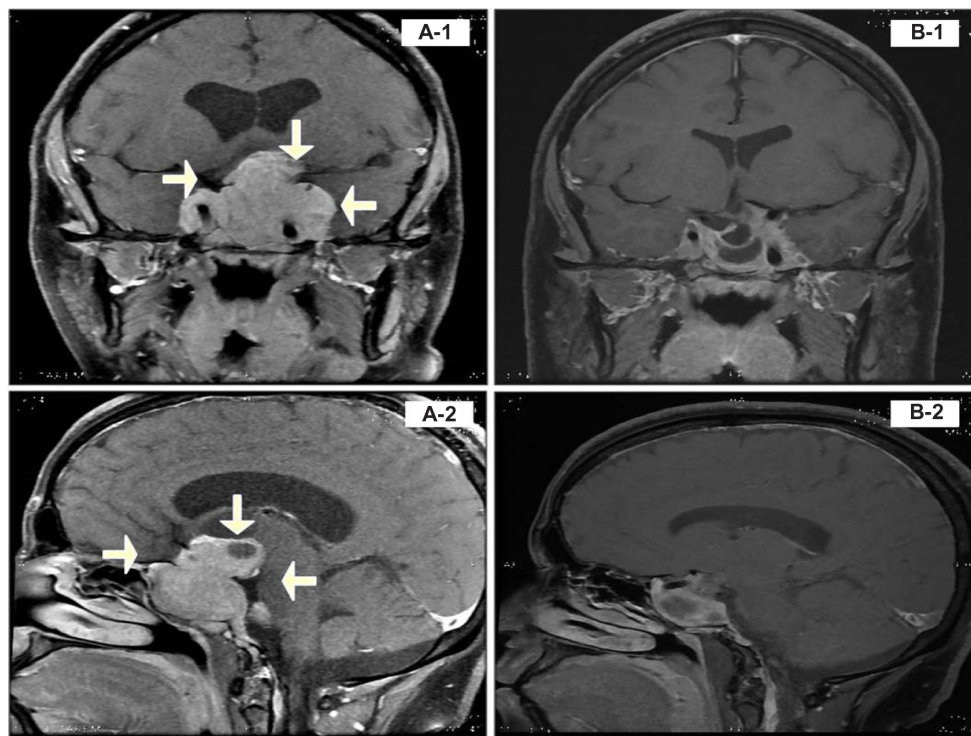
Sagittal and frontal T1 MRI before (A-1 and A-2), and after treatment with Cabergoline (B-1 and B-2).
